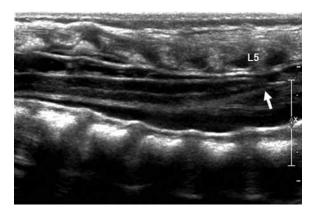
Tethered cord. Longitudinal sonogram shows low-lying conus *(arrow)* at the L5 vertebra. Note that the cord and nerve roots are positioned posteriorly.
